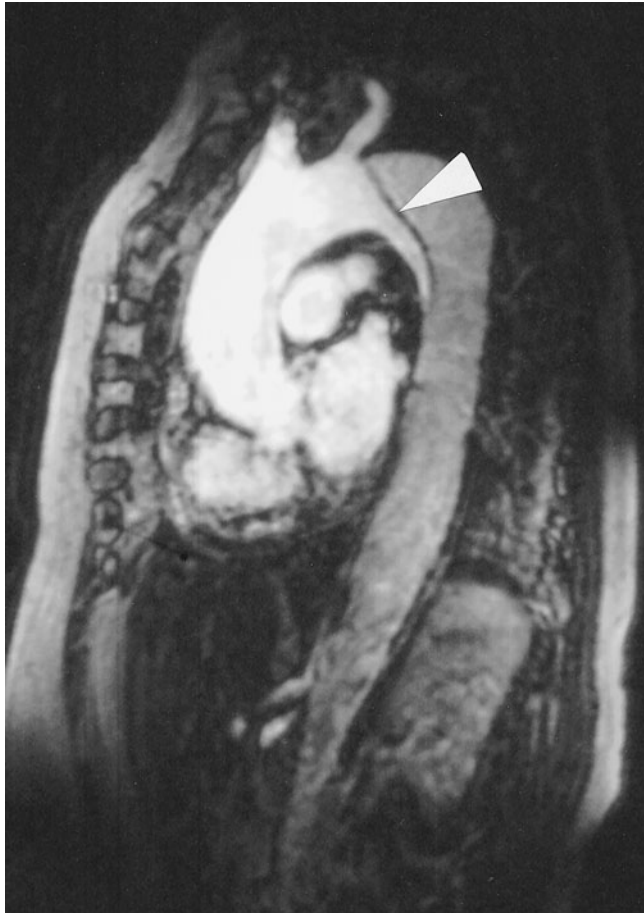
Sagittal contrast-enhanced magnetic resonance image of a chronic type B dissection. The dissection flap (arrowhead) is clearly identified and the false lumen appears to extend the entire length of the thoracic and abdominal aorta (darker posterior lumen).
